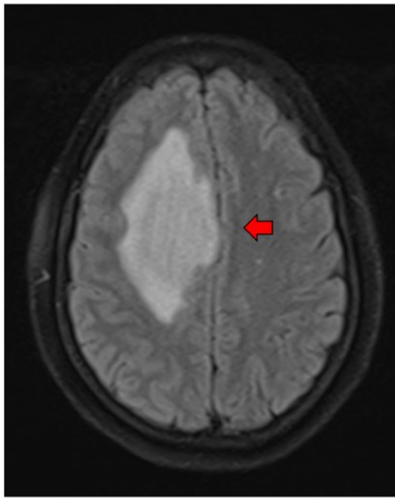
FLAIR in axial plane
